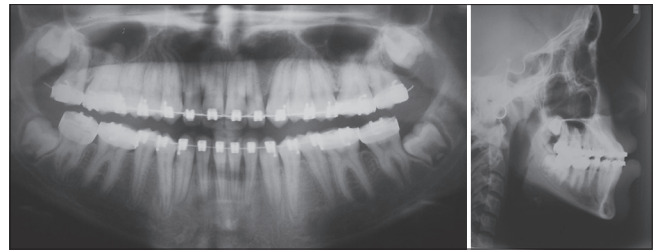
Progress radiographs
